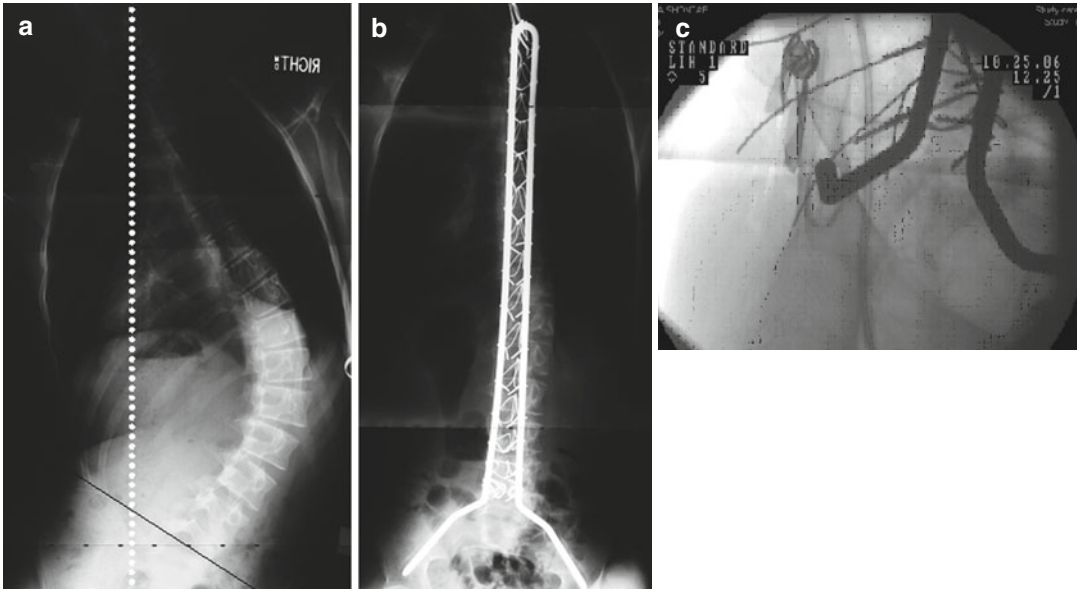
(a, b) Preoperative and postoperative PA sitting radiographs of an ambulatory child with cerebral palsy scoliosis after posterior spinal fusion with the unit rod. Note the restoration of truncal balance and pelvic obliquity. (c) Intraoperative view of a pelvic limb of the unit rod placed between the inner and outer table of the ilium, in the “teardrop”
